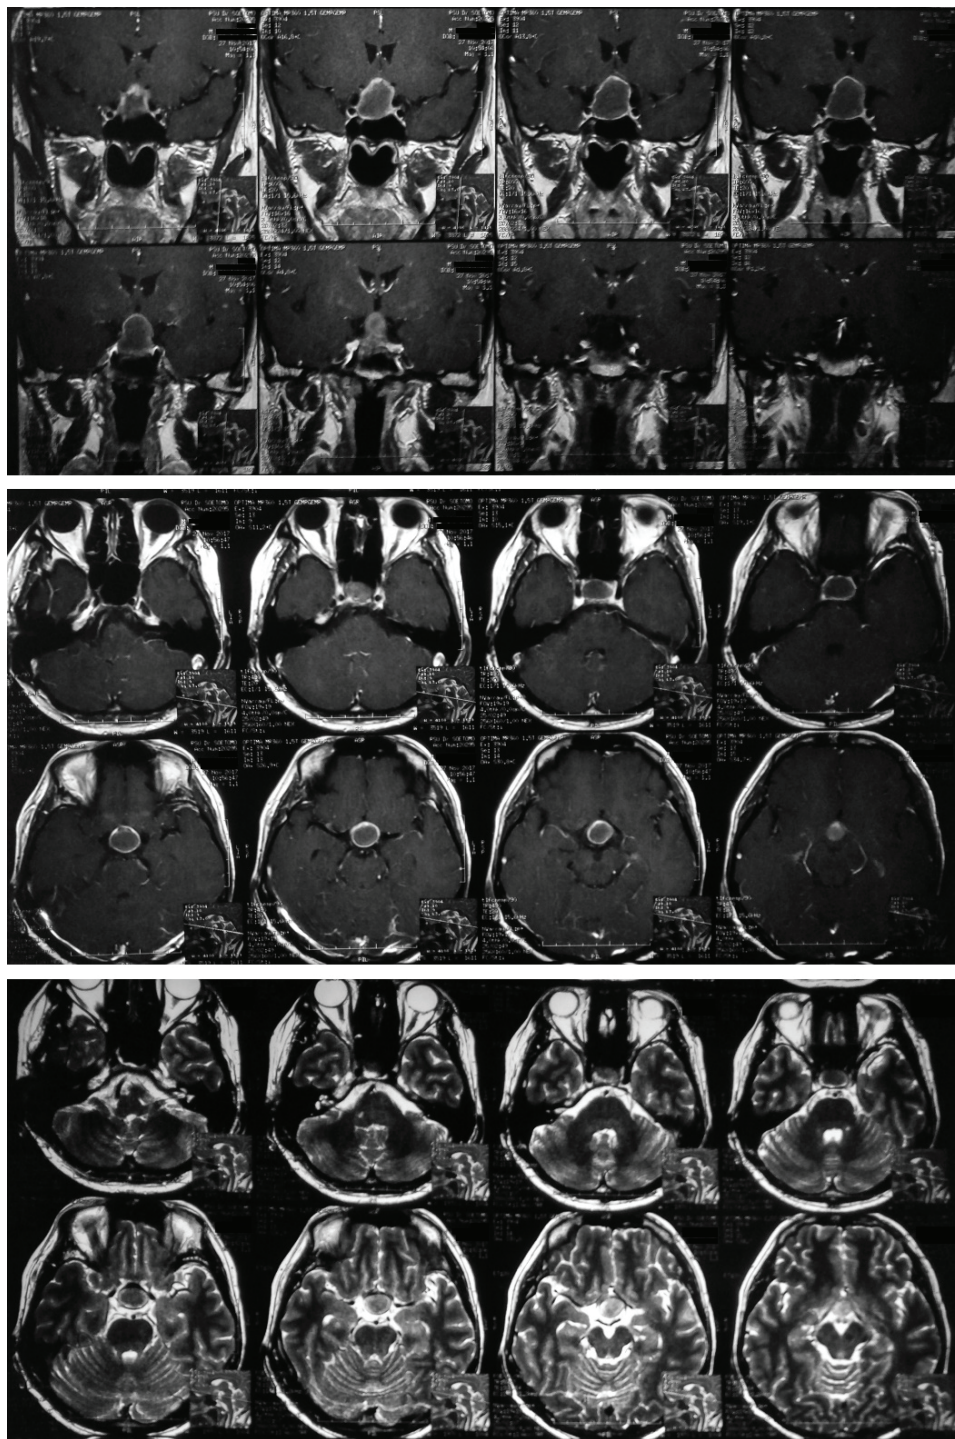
Contrast MRI of the brain on various planes and sequences. (top) T1-weighted coronal. (middle) T1-weighted axial. (bottom) T2-weighted axial.
